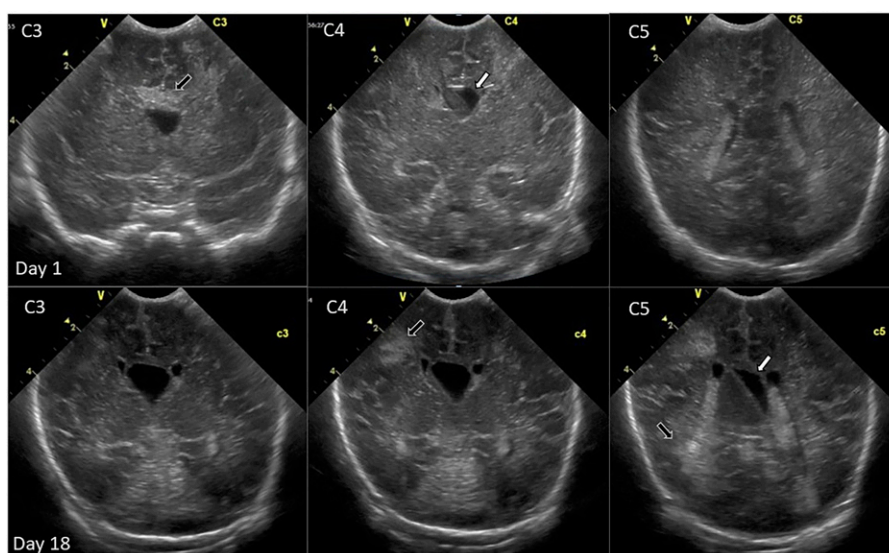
Top row: Coronal section of cranial ultrasonographic images obtained on day 1 after birth. Note the focal hyperechoic area in the anterior aspect of the corpus callosum (black arrow), suggestive of a periventricular bleed. A fluid-fluid level in the cavum vergae (white arrow) indicates intraventricular hemorrhage. Bottom row: Coronal section of cranial ultrasonographic images obtained on day 18 after birth. Note the ventricular dilation (white arrow) and multiple areas of echogenicity in the frontal and parieto-occipital regions (black arrow), suggestive of progression of hemorrhage when compared to previous images.
